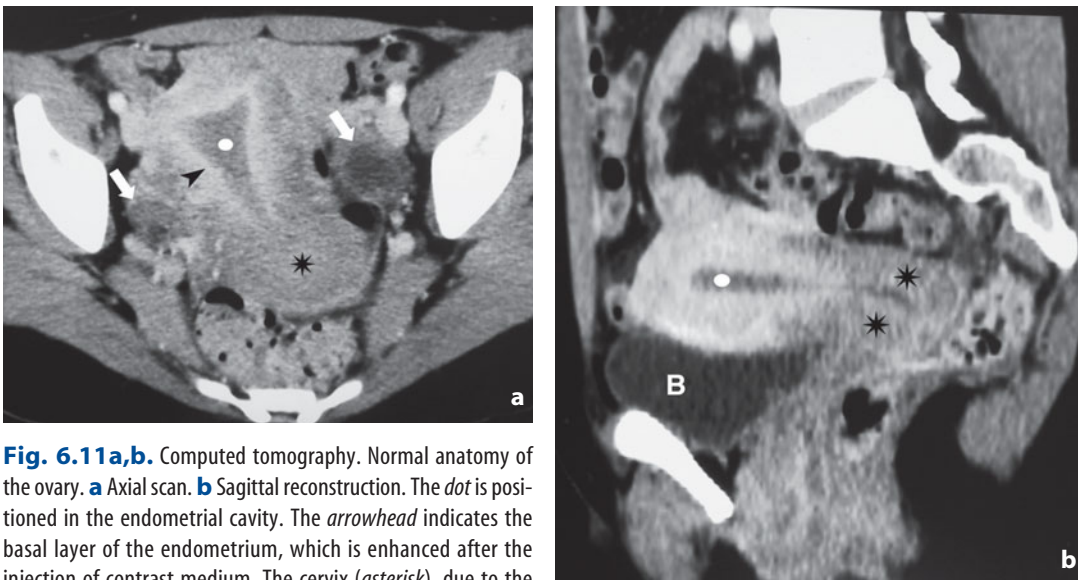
Computed tomography. Normal anatomy of the ovary. a Axial scan. b Sagittal reconstruction. The *dot* is positioned in the endometrial cavity. The *arrowhead* indicates the basal layer of the endometrium, which is enhanced after the injection of contrast medium. The cervix (*asterisk*), due to the greater stromal component, appears hypoattenuating in comparison to the myometrium of the uterine body and fundus. The *arrows* indicate the ovaries. *B*, urinary bladder
